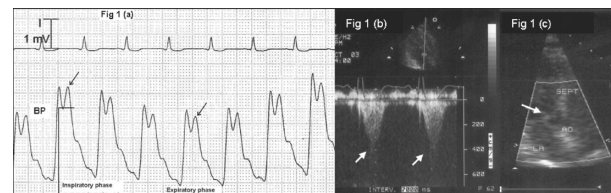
A, Blood pressure (BP): bisferiens arterial pulse (arrows), pulse pressure variation, 35%. B, Continuous wave Doppler analysis of the subaortic flow: subaortic flow acceleration with dagger blade shape (arrows). C, systolic anterior motion (arrow); Left atrium (LA), aortic root (AO), interventricular septum (SEPT).
